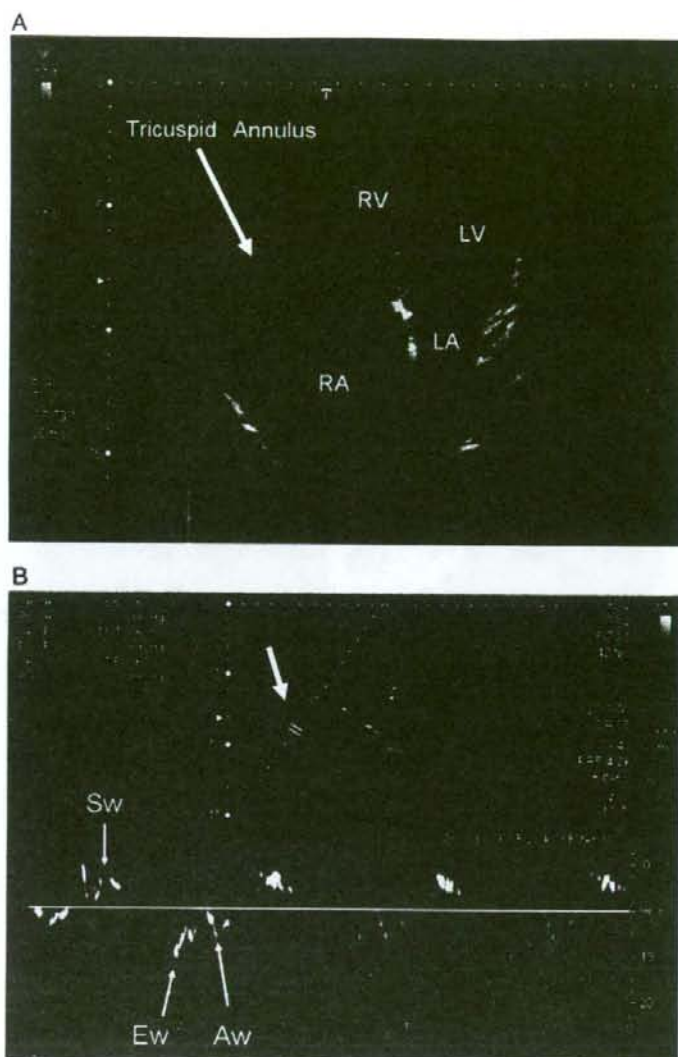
These are examples of Doppler tissue images recording at the tricuspid annulus in the apical four chamber view (A). By putting a reference point on the tricuspid annulus on A, we could obtain a clear spectral Doppler recording of myocardial velocity at the tricuspid annulus (B). The early systolic velocity (Sw) and diastole myocardial velocity (Ew) at the tricuspid annulus can be observed in B. Sw was identified as the peak systolic velocity, Ew was identified as the early diastolic velocity, and Aw was identified as the late diastolic wave. RV, RA, LV, and LA indicate the right ventricle, right atria, left ventricle and left atria, respectively.
